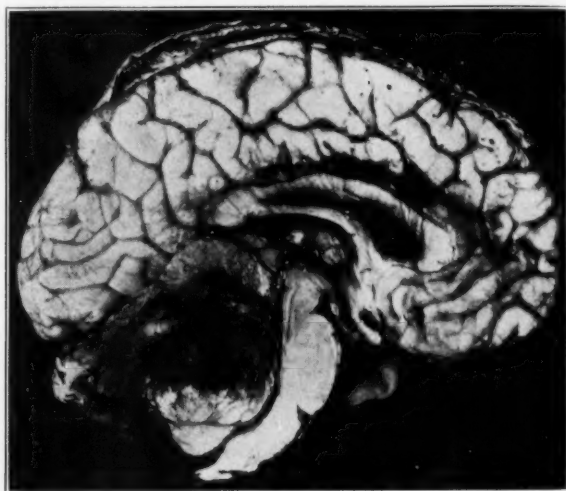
(case 3).—Hemorrhage into a medulloblastoma. One year before death an operation was performed, followed by intensive roentgen treatment.
